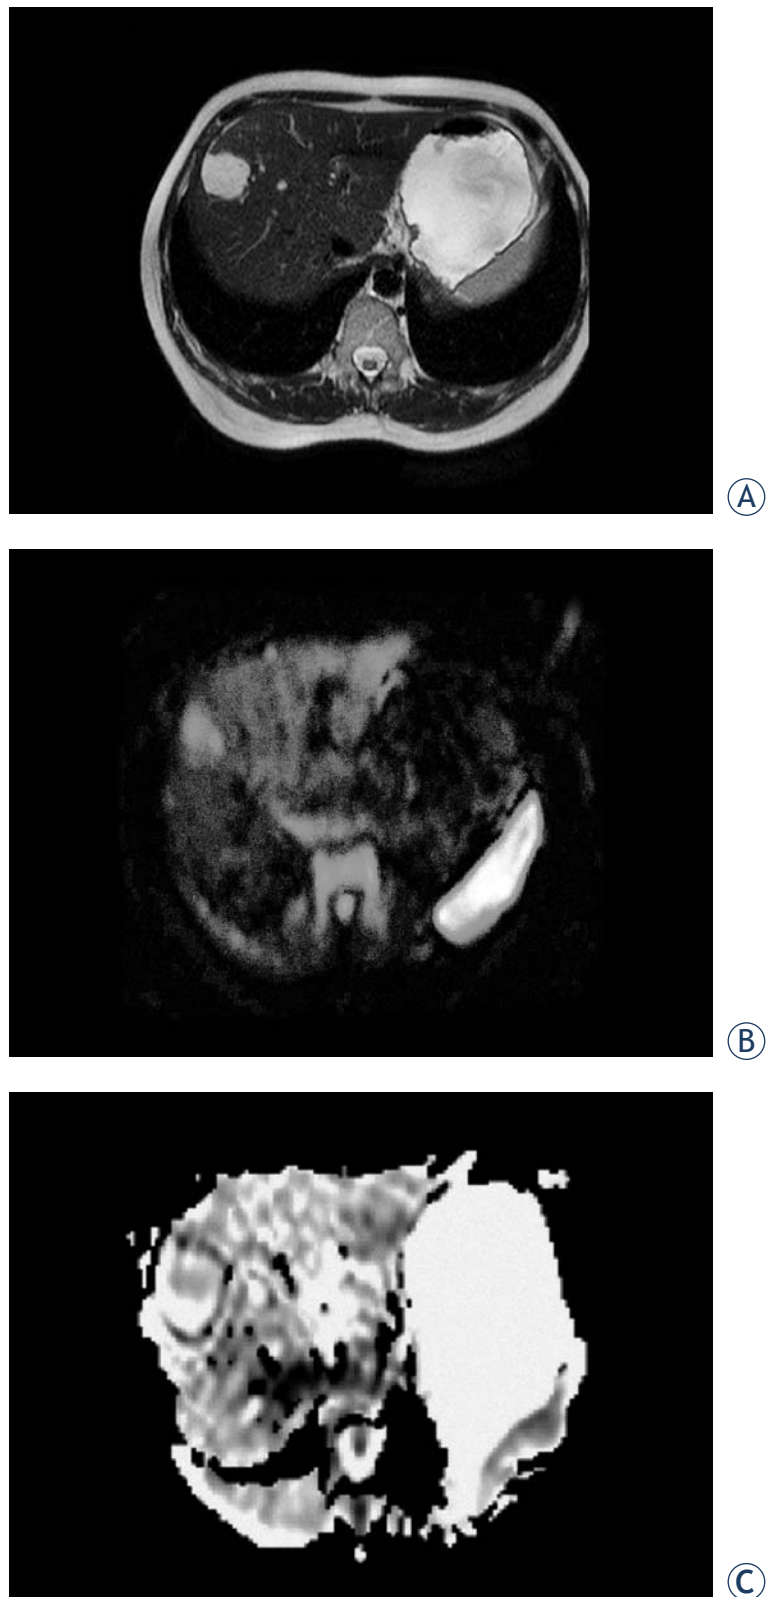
44-year-old woman with a haemangioma of the liver. Axial T2-weighted TSE (A) MR image shows a haemangioma in the right lobe of the liver. This haemangioma appears isointense relative to the liver on the diffusion-weighted image with b factor 1000 sec/mm² (B). ADC map. Lesion-to-liver ADC ratio=1.9 (C).
